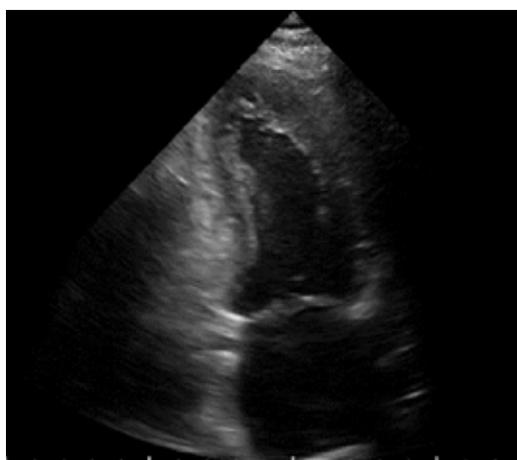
Apical 2-chamber image. There is no pericardial effusion or areas of thinning.
